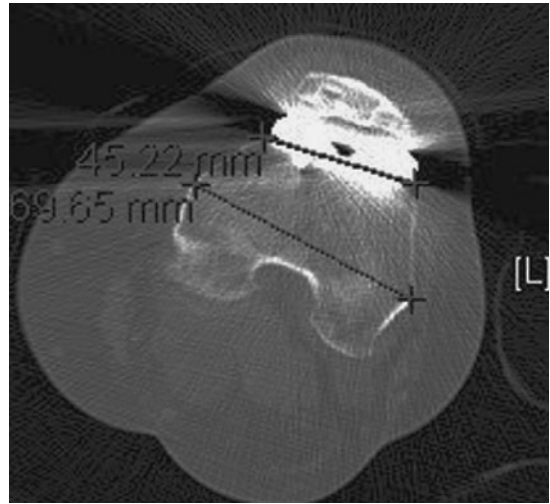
A computed tomography scan from a patient who had persistent lateral pain. The trochlear component is internally rotated; this could not be detected radiologically
